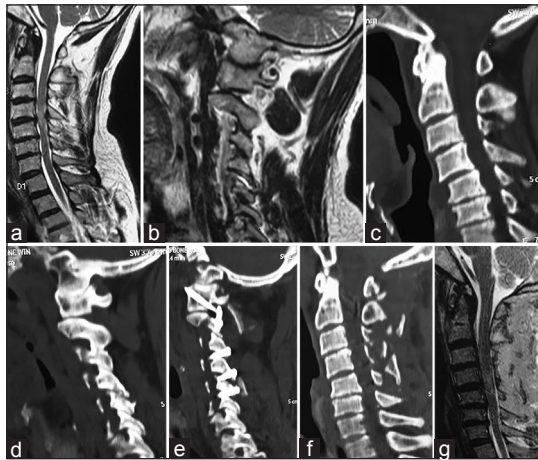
Images of a 65-year-old male patient. (a) T2-weighted MRI shows multilevel spondylotic changes. (b) MR image with slice through the facets. It shows posterior atlantoaxial facetal dislocation. (c) CT showing the cervical spine and the degenerative changes. (d) CT with slice through the facets showing posterior atlantoaxial facetal dislocation. (e) Postoperative scan showing atlantoaxial facetal alignment. Atlantoaxial and subaxial instrumentation can be seen. (f) Postoperative CT. Bone graft pieces can be seen in the midline. (g) Postoperative MRI. MRI = Magnetic resonance imaging, CT = Computed tomography
